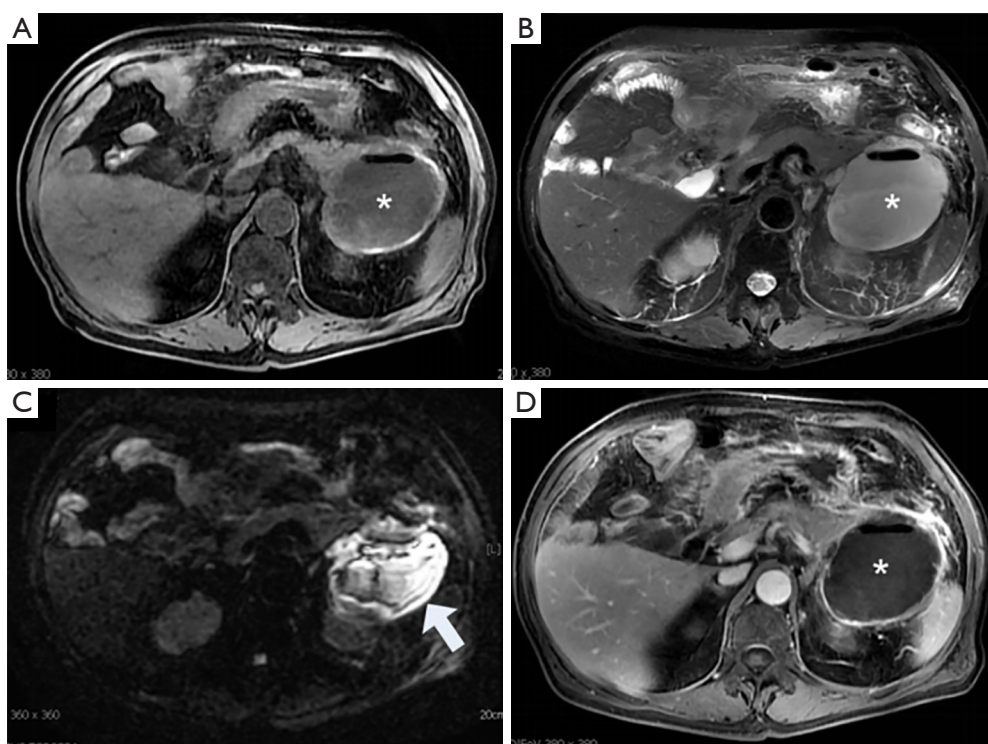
A 67-year-old female with acute pancreatitis 7 weeks after onset. Infected WON in the tail of the pancreas was confirmed by fine needle aspiration biopsy. The T1WI (A) and T2WI (B) show an encapsulated, ill-defined collection (asterisk) in the tail of the pancreas with wall thickening and gas within the collection. With DWI, the collection shows hyperintensity (C, arrow) (C), and the wall was enhanced after contrast injection (D). WON, walled-off necrosis; DWI, diffusion-weighted imaging.
